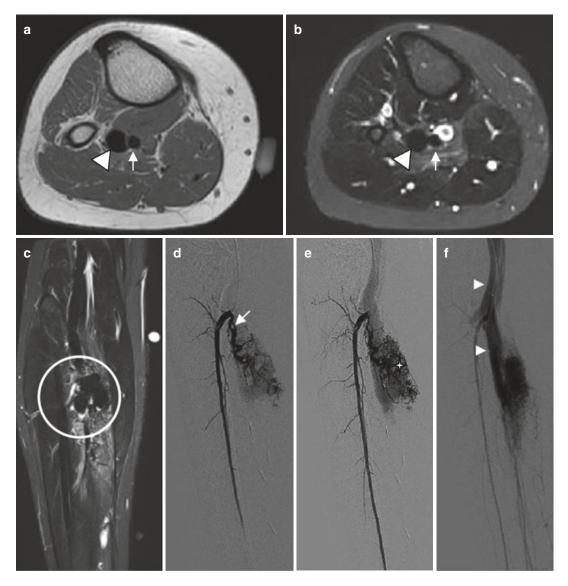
Complex arteriovenous malformation affecting the calf in a 15-year-old woman. (a) Axial T1-weighted MR image. (b) Axial T2-weighted MR image with fat suppression. (c) Coronal T2-weighted MR image with fat suppression. (d–f) Conventional angiographic images acquired from early arterial phase to venous phase. (a, b) Signal voids in the high flow vessels can be depicted on both T1-weighted and T2-weighted MR images, including the feeding artery (*arrow*) and arterialized draining vein (*arrowhead*). (c) Coronal T2-weighted MR image reveals the nidus (*circle*). (d–f) Arteriogram acquired demonstrates a slightly enlarged tortuous artery (*arrow*) during the early arterial phase, the nidus (*star*) on late arterial phase, and then enlarged draining veins (*arrowheads*)
